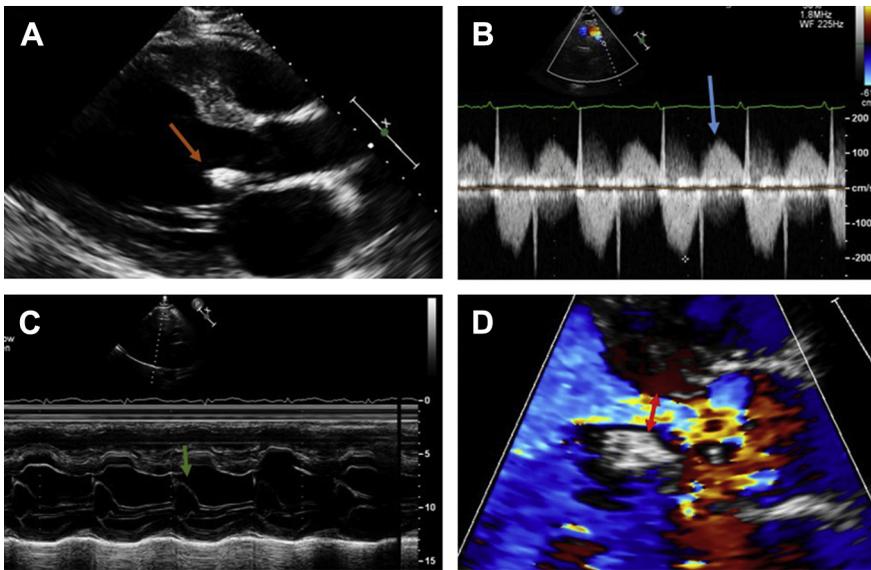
Aortic regurgitation (AR). (A) Large vegetation (arrow) on the noncoronary cusp of the aortic valve (AV) causing severe AR. (B) Holodiastolic flow reversal in the descending aorta (arrow). (C) M-mode parasternal long axis showing early diastolic closure of the mitral valve (arrow) owing to the large AR jet. (D) Large vena contracta of the severely regurgitant AR jet (arrow).
